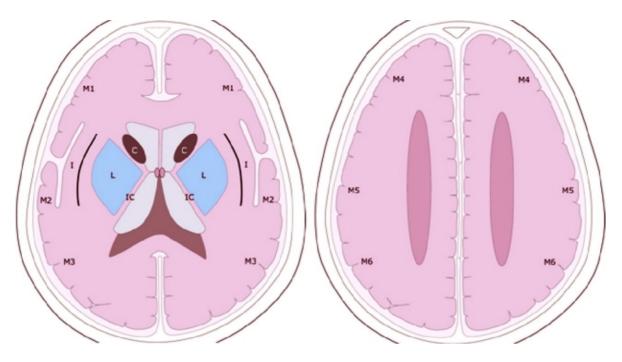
ASPECTS and PECTS templates. C=caudate; L=lentiform; IC=internal capsule; I=insular ribbon;
